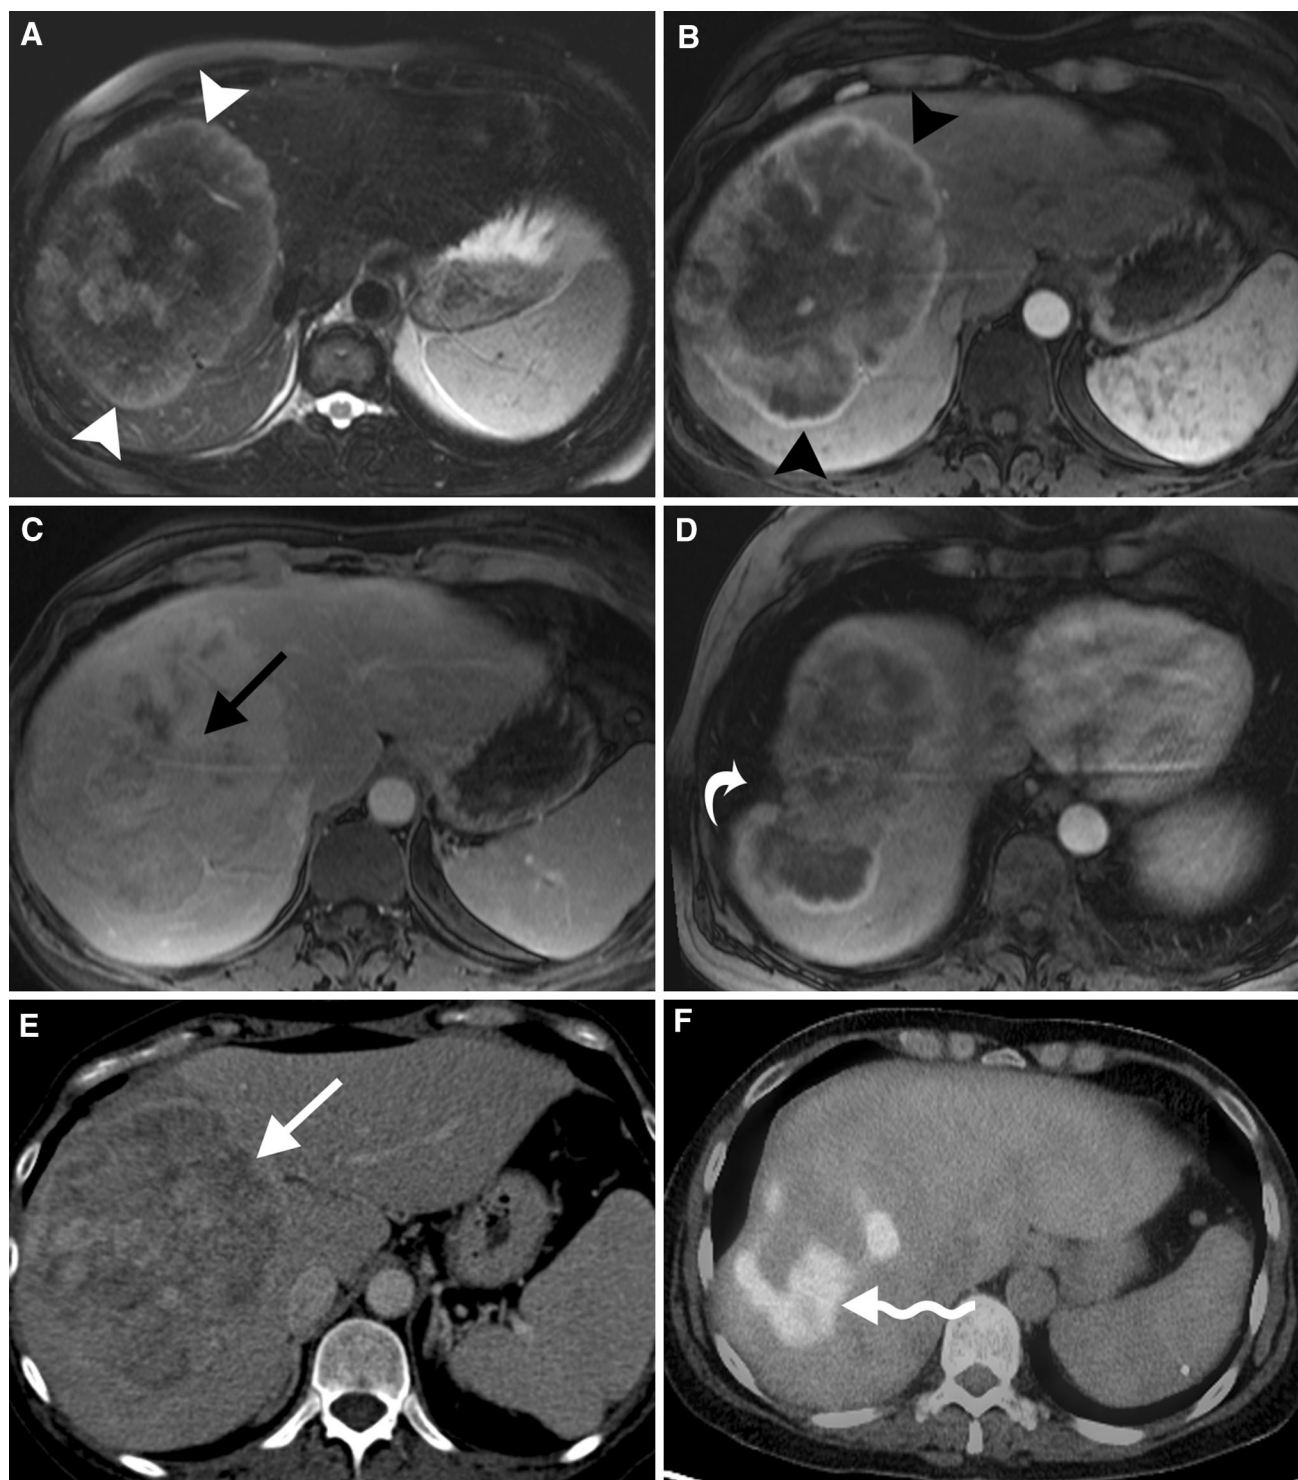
CHC in a 58-year-old noncirrhotic woman with imaging features more typical of CC. A Axial T2 inversion-recovery MRI demonstrates a heterogeneously T2 hyperintense mass in the right hemiliver (*white arrowheads*). B–D Axial T1 VIBE contrast-enhanced arterial and 5-min-delayed MRI demonstrates peripheral arterial enhancement (*black*
